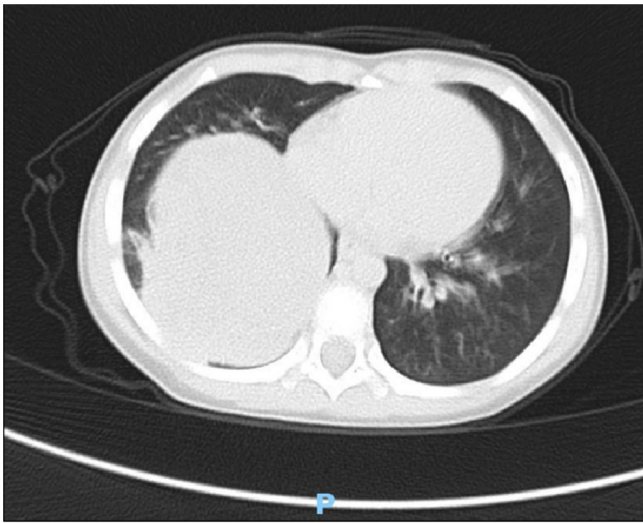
Chest CT plain scan shows a mass of ~85x74x68 mm in size in the lower right chest with uneven density and clear boundaries.
